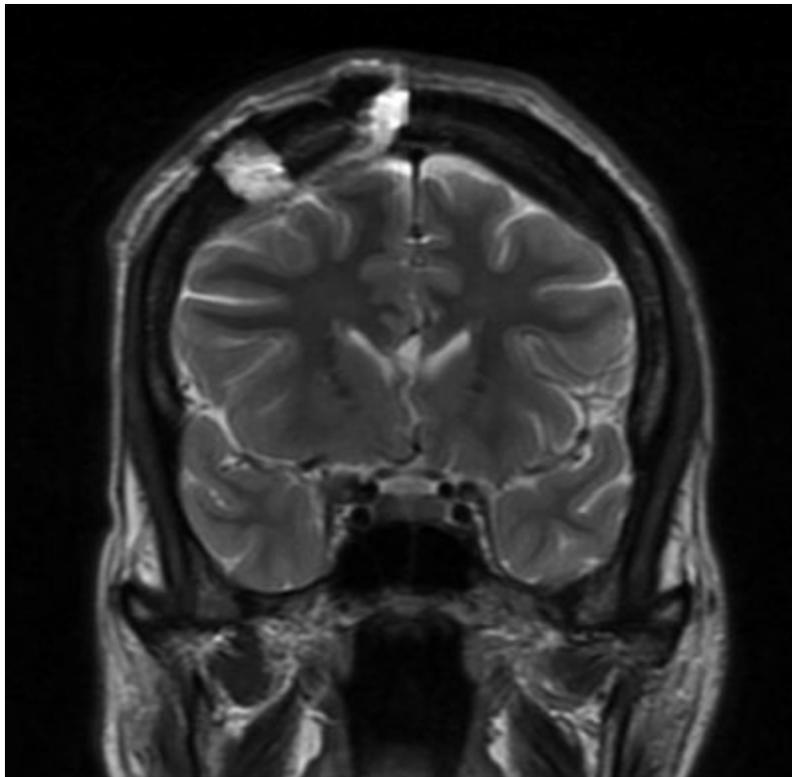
Coronal T2 magnetic resonance image showing the position of the craniotomy and the division of the genu into the midline cavum.
